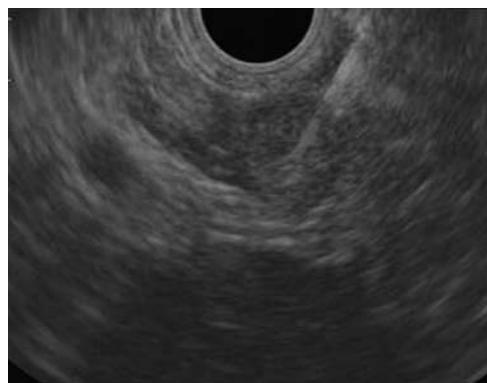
Endoscopic ultrasound-guided fine needle aspiration of a left adrenal mass in a patient with lung cancer.
